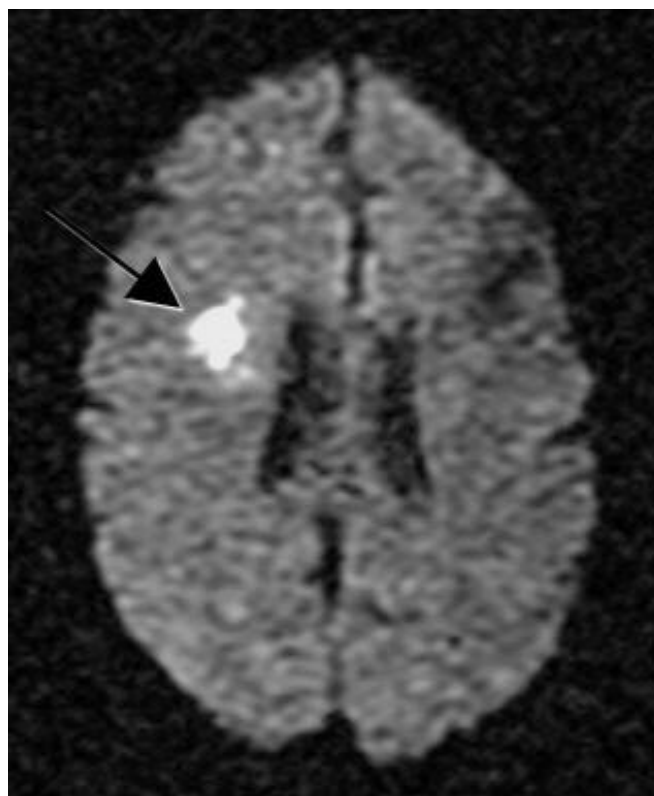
Brain MRI without contrast (axial DWI sequence): Showing bright signal in right parietal and right centrum semiovale (arrow).
